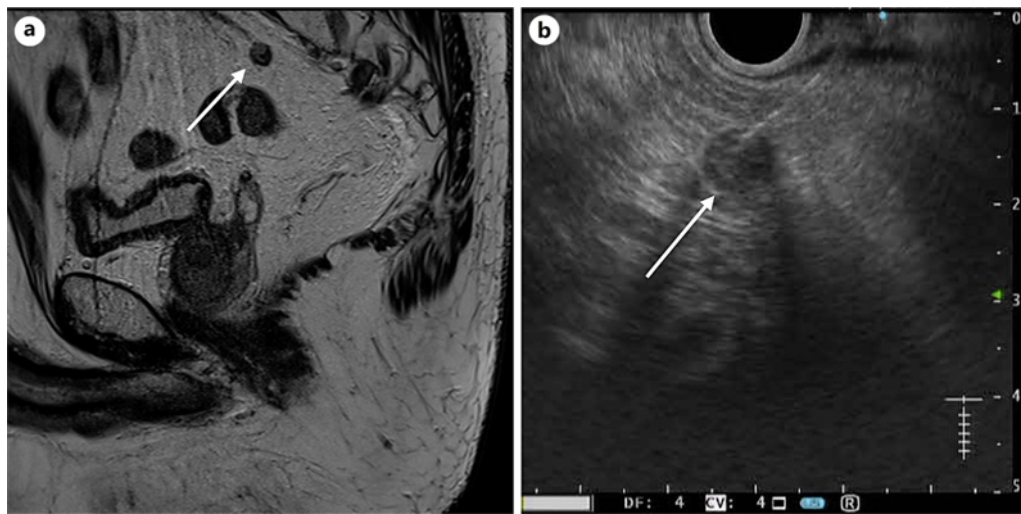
a, b MRI and EUS-FNA images of a suspected presacral lymph node.
